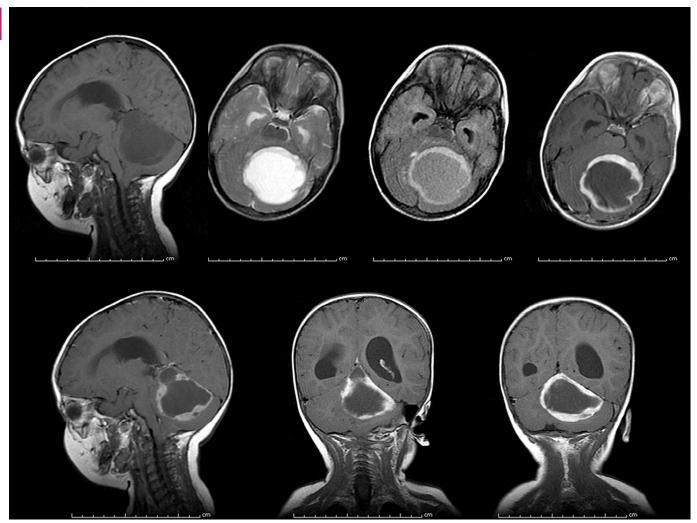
Pilocytic astrocytoma in a child. *Upper panel* (*left to right*): Sagittal T1, axial T2, axial fluid-attenuated inversion recovery, and postcontrast axial T1-weighted images. *Lower panel*: Postcontrast sagittal and coronal T1-weighted images. A T1 hypointense and T2 hyperintense peripherally enhancing cystic posterior fossa cerebellar mass lesion effaces the fourth ventricle, resulting in hydrocephalus.
